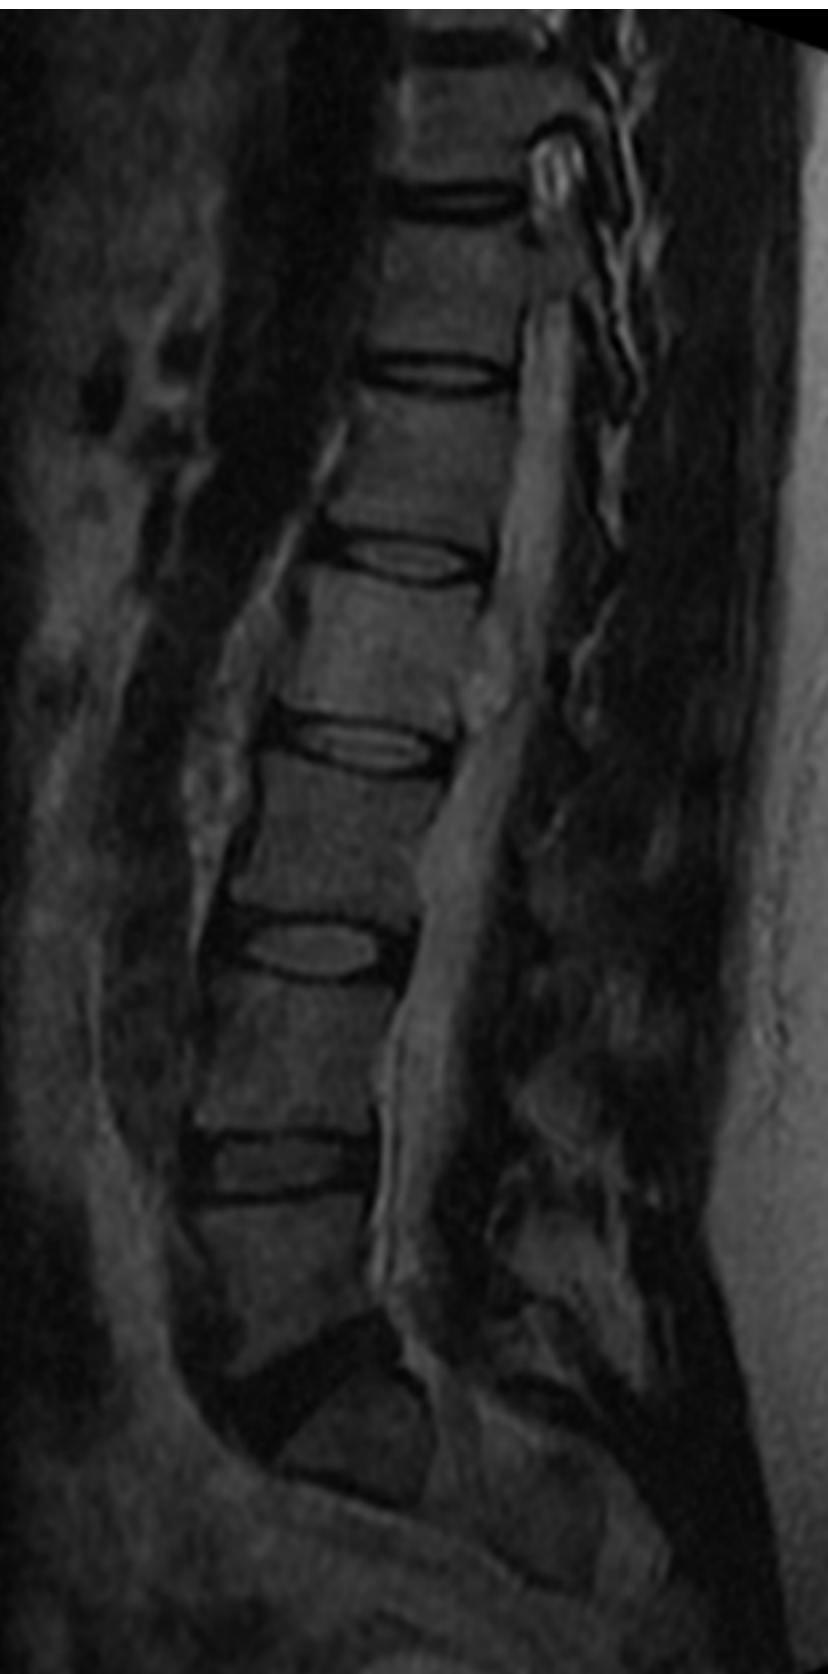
Patient's MRI showing an epidural mass measuring 2.4 cm x 0.9 mm x 0.6 mm behind the L2 vertebral body and a high signal area behind the uterus that could be a cyst or solid ovarian mass measuring approximately 3.6 cm.
